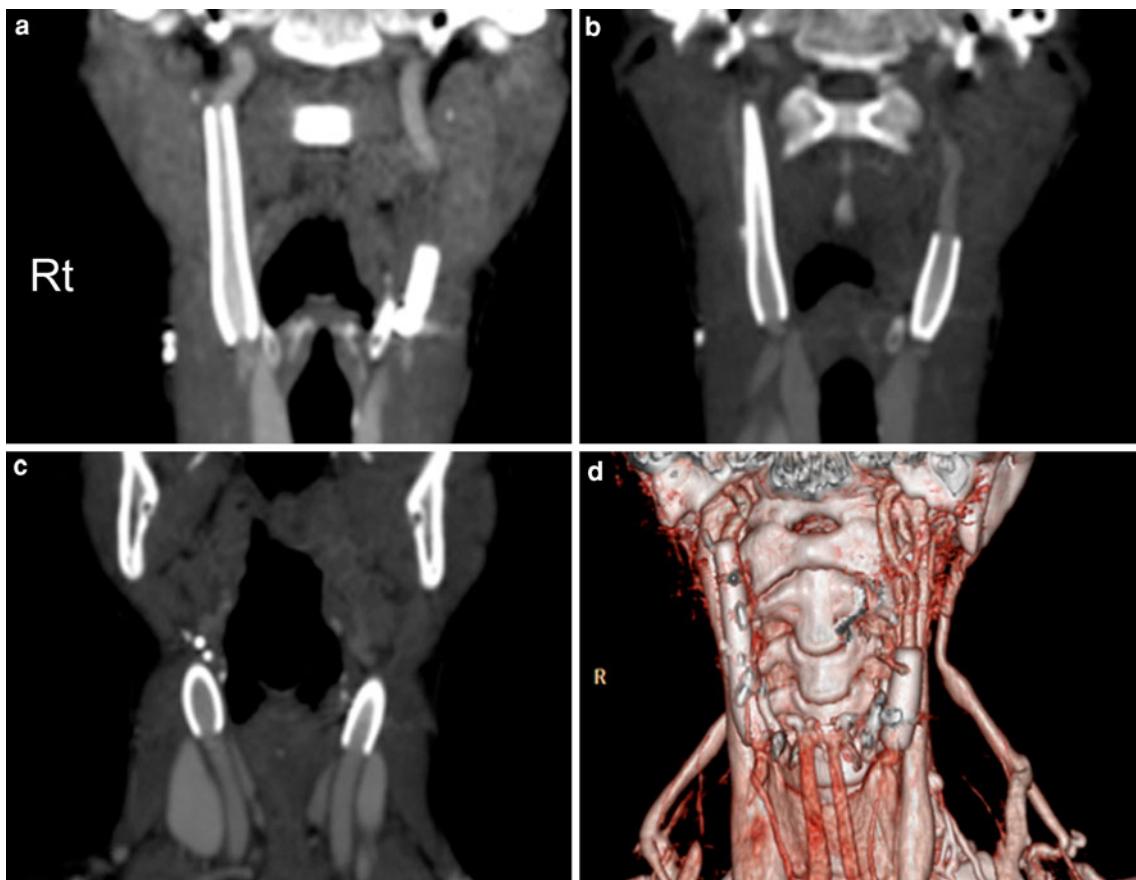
Postoperative high resolution CT scan shows bilateral stable deployment of the inserted stents (a–c coronal view, d 3-dimensional reconstruction)
